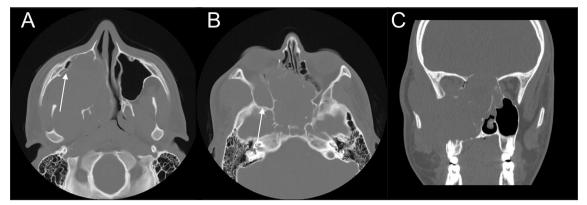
Axial CT images show bone remodeling, thinning, and destruction that involve the posterior margin of sphenopalatine foramen extending to the base of the medial pterygoid plate, right maxillary sinus, right nasal cavity, ethmoid sinuses, sphenoid sinuses, anterior skull base and right portion of the hard palate. Note the anterior bowing of the posterior wall and flattening of the right maxillary sinus (arrow in A). Moreover, enlargement of the right inferior orbital fissure in comparison to the left side is evidenced (arrow in B)
